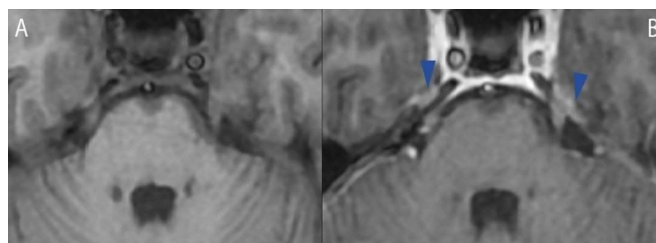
(A) Axial T1-weighted MRI without contrast. (B) Axial T1-weighted contrast-enhanced MRI showing slight bilateral enhancement along the trigeminal nerves (blue arrowheads).
